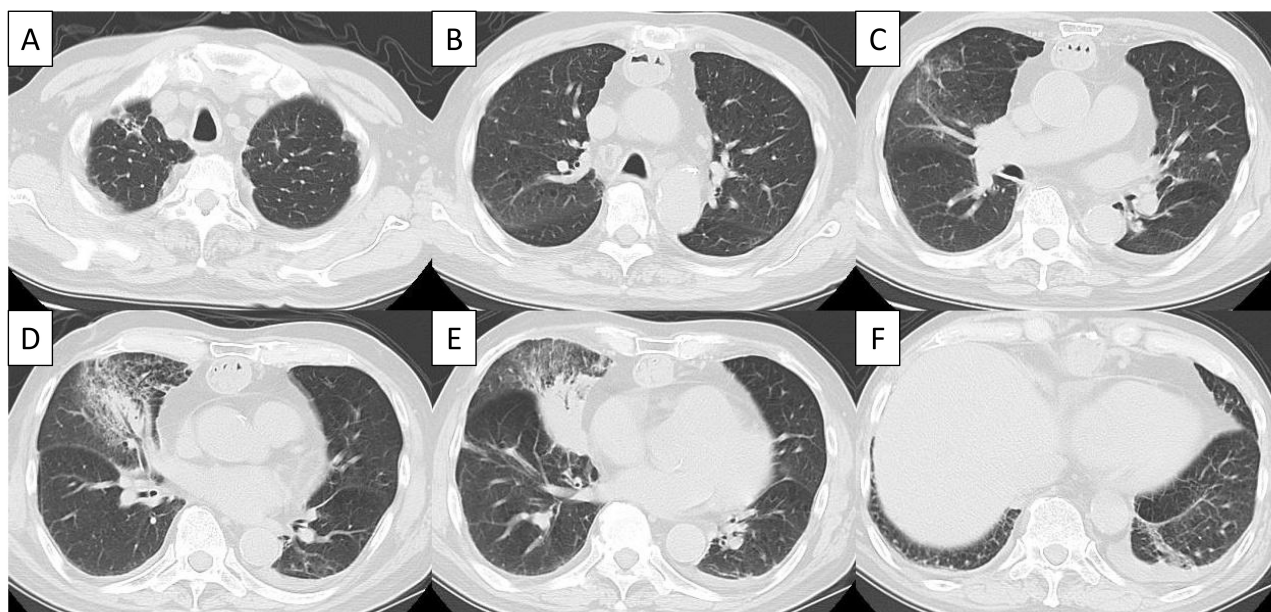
Chest computed tomography on admission. (A–C) Multifocal bilateral ground-glass opacities are distributed predominantly in the peripheral and subpleural lung fields. (D, E) A relatively well-defined consolidation with air bronchograms is present in the right middle lobe in a peribronchovascular distribution, accompanied by adjacent faint ground-glass and reticular opacities. (F) A small subpleural band-like opacity is present in the left lower lobe, with trace bilateral pleural effusions.
